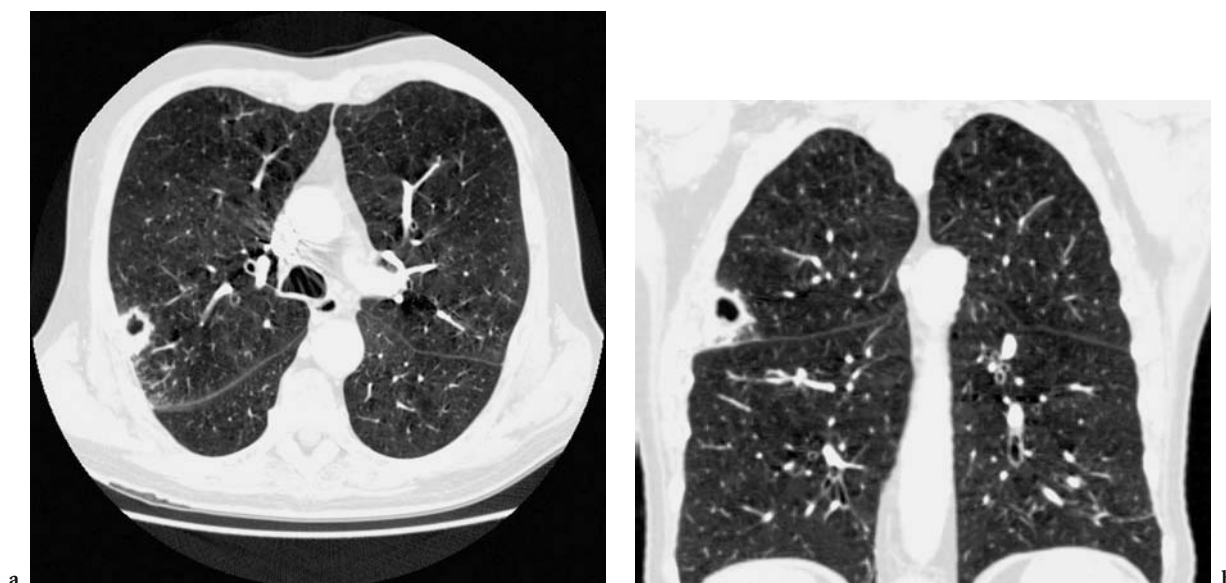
Nocardia* infection in a 67-year-old man. a Chest CT scan (collimation 4×1.25 mm) shows a cavitary nodule in right upper lobe which extends to the costal pleural surface. b Coronal reformatted image shows relationship of nodule to adjacent major fissure
